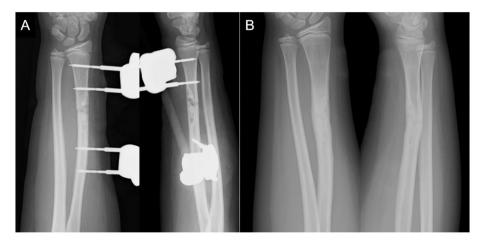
Radiographs immediately after surgery (a). Radiographs at 6 months after surgery showing bone union (b).
